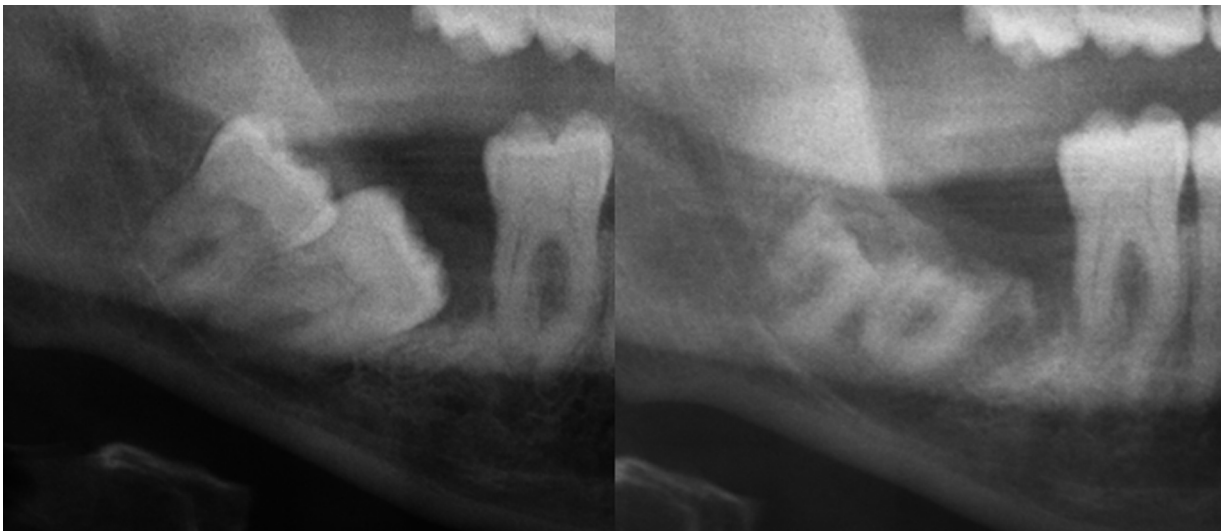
Left side: Preoperative radiograph of LR7 with primary failure of eruption and impacted LR8. Right side: 22-month postoperative radiograph after coronectomy of LR7 and LR8 showing that the roots are free of disease, and the roots of LR7 have migrated 4 mm.
